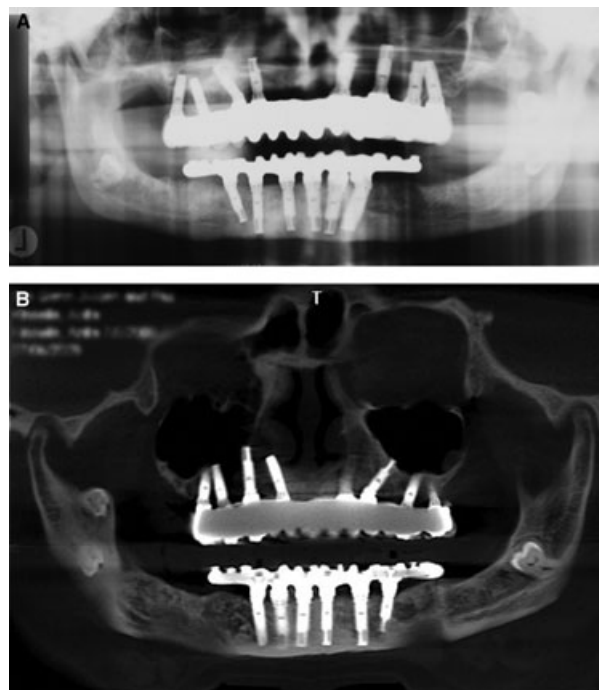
(A) Panoramic radiograph following definitive prosthesis delivery. (B) Follow-up panoramic radiograph 5 years postoperatively.
